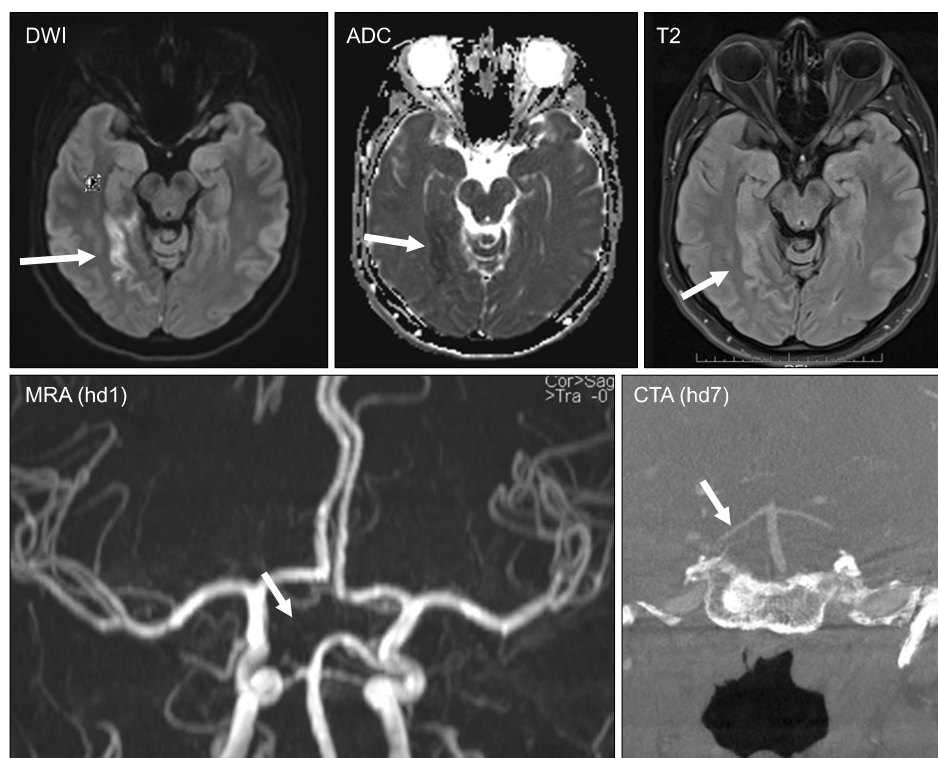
MRI showing a subacute ischemic stroke in the territory of the right PCA (upper panels) in a 38-year-old female 18 days after the second Moderna vaccine dose. MRA on admission shows discontinuation of the right P1 segment (lower left panel). Normal flow in both PCAs was documented on CTA after 7 days of nimodipine.
